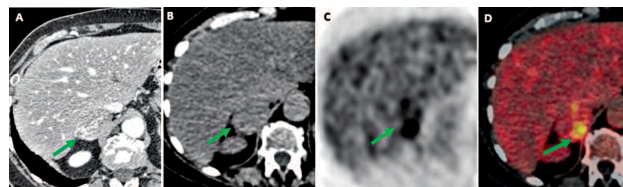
A 74 years old man affected by right adrenocortical carcinoma. Computed tomography transaxial image A) showed a 4.5cm solid adrenal mass characterized by an inhomogeneous enhancement after contrast enhancer injection (green arrow). Fluorine-18-FDG PET/CT axial CT, PET and fused images (B, C and D) confirmed the presence of the lesion (green arrows) with focal and intense ^{18}F -FDG uptake in the medial portion of the mass (SUVmax of 6).
